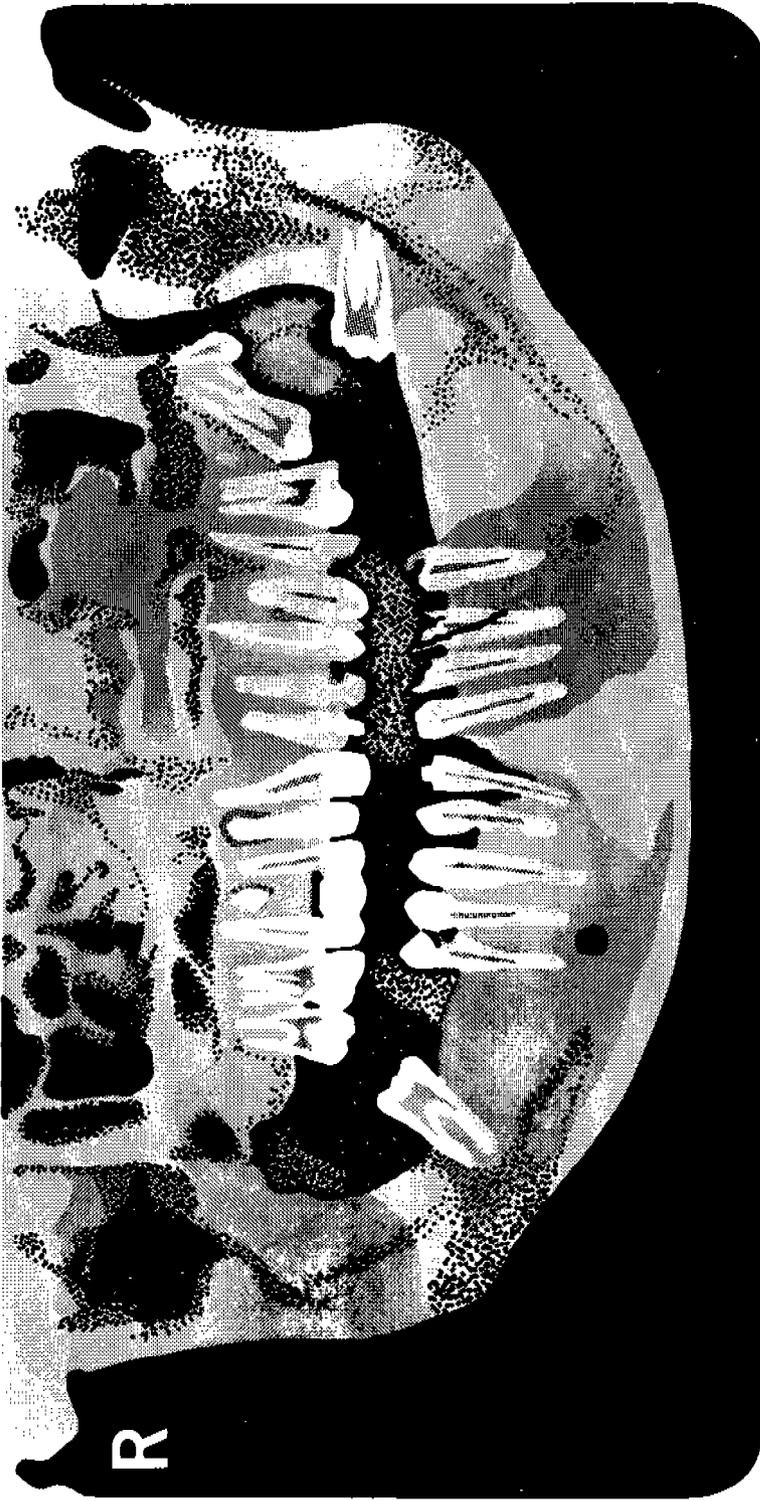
Panoramic radiograph of the patient taken during initial dental processing.
